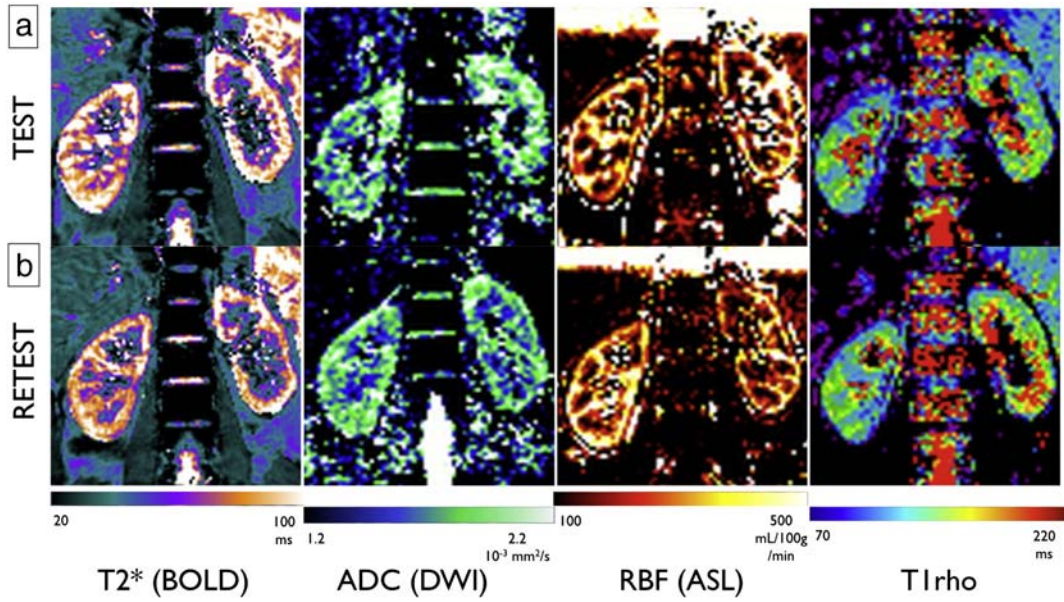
Renal MRI scans of the 4 quantitative MRI modalities with repeated scans (a and b) in a lupus nephritis patient.
